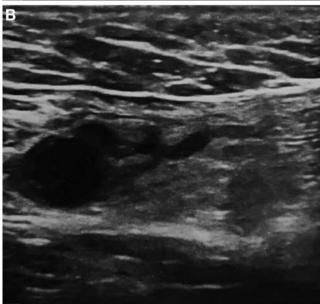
Ultrasound views of spermatic vein thrombosis.
